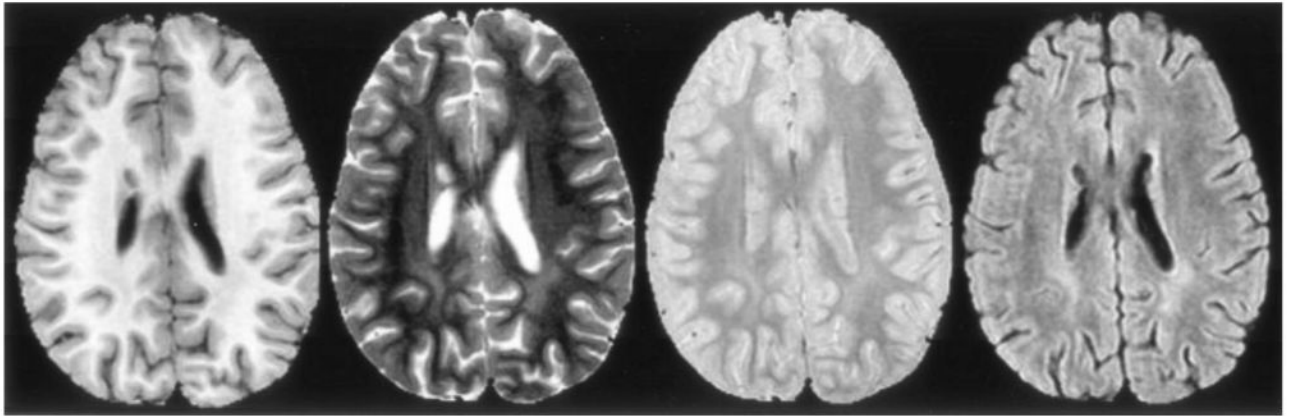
T1-, T2-, and proton density-weighted and FLAIR images (*left to right*) from a typical examination. LE can be seen in the white matter posterior to the ventricles.
